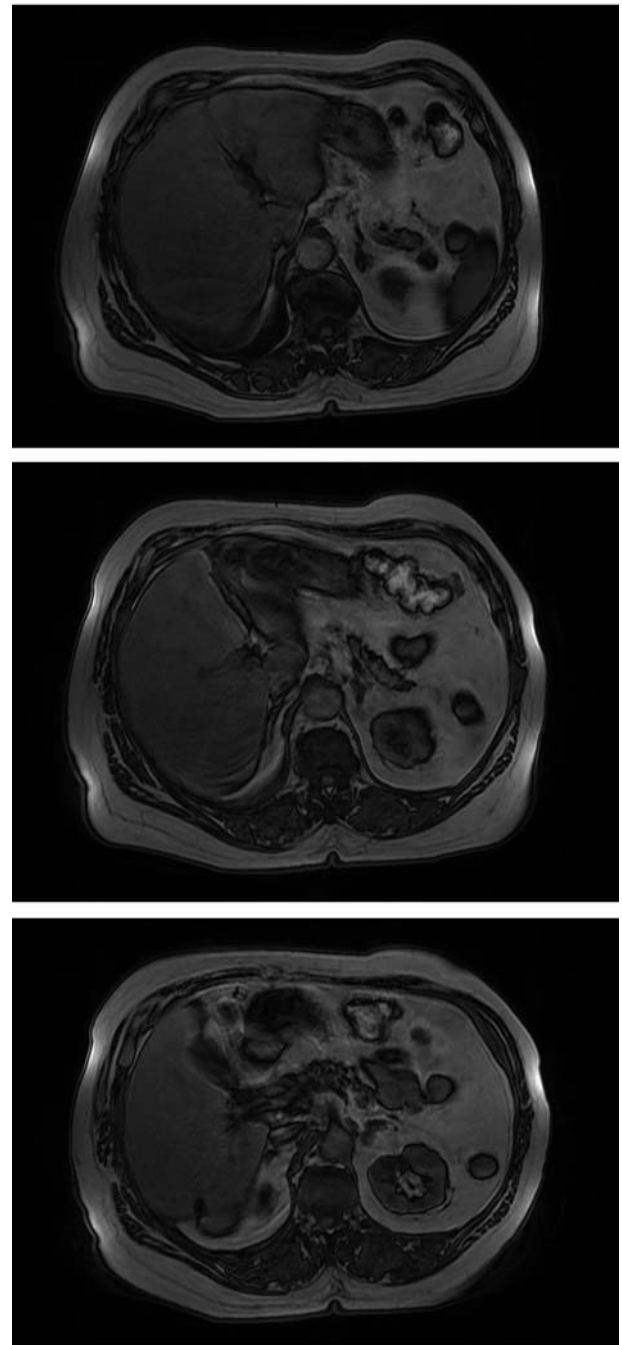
MRI scan of March 2012 revealing no liver tumor.
